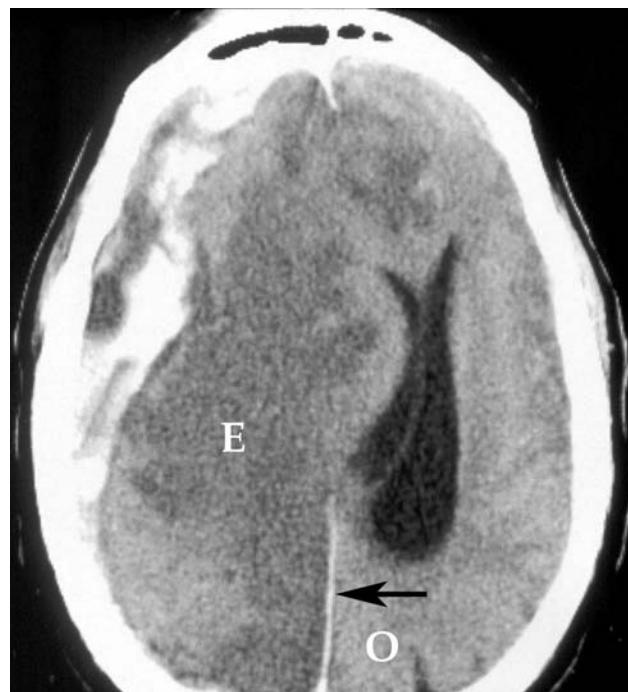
This CT scan shows the effects of edema. A large, acute subdural hematoma (white mottled crescentic shape) is present on the right side of the calvaria. There is massive edema (E) in the ipsilateral brain that has created a midline shift of the brain beneath the falx cerebri (arrow). Note the entire right lateral ventricle has been pushed across the midline. Frontal sinuses (dark areas) can be seen in the frontal bone. O, occipital lobe.
